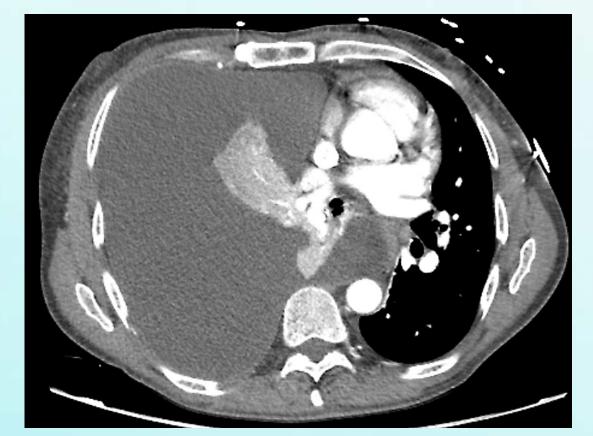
CT chest demonstrating a large right pleural effusion with a collapsed right lung.
